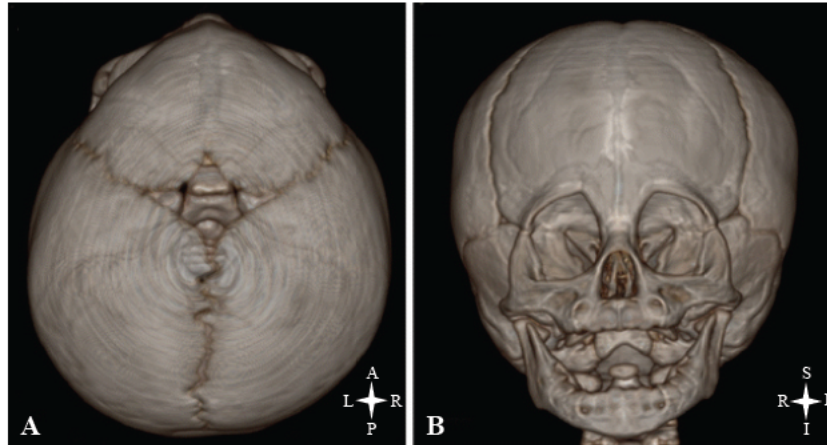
CT scan showing a superior (A) and anteroposterior (B) view of trigonocephaly
